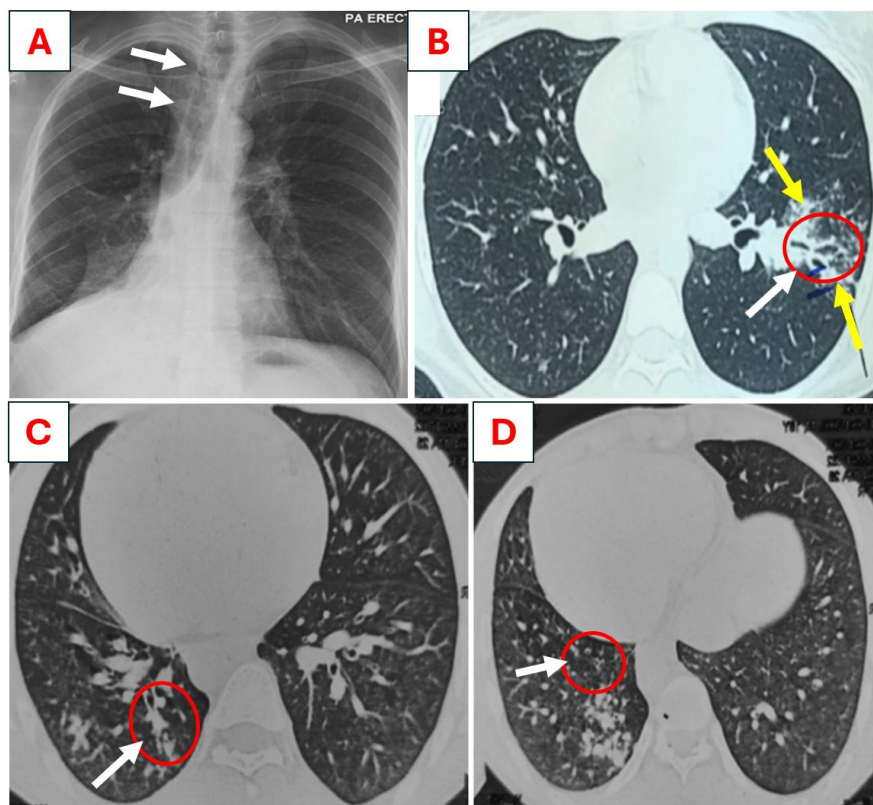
Radiologic Findings of EBTB. (A) Atelectasis of the Right Lung on Chest X-Ray; (B) Left Lung Nodules and Bronchiectasis on Thoracic CT Scan ; (C) Features of Tree in Buds on right Lower Lobe with High-Resolution Computed Tomography (HRCT); (D) Right Lower Lobe Nodules on HRCT
